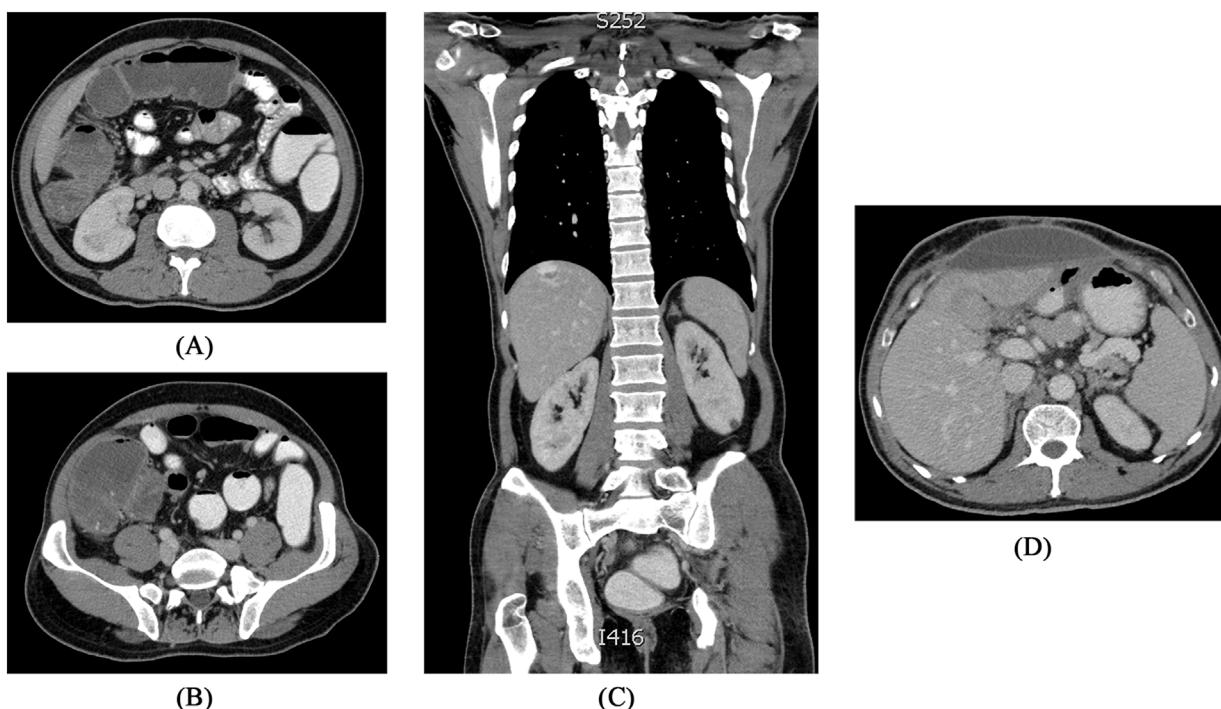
(A–B) A contrast-enhanced CT scan showing a mass involving the splenic flexure extending for approximately 5.2 cm in length. (C–D) Anterior abdominal wall collection with a thick wall measuring $13 \times 3.5 \times 9$ cm on its maximum transverse likely to be seroma. The liver is enhancing homogeneity and appears to be pulled to the anterior abdominal wall likely due to fibrosis, stable hemangioma at segment VII measuring 2.6 cm in diameter. The small bowel is the anterior abdominal wall without obstruction.
